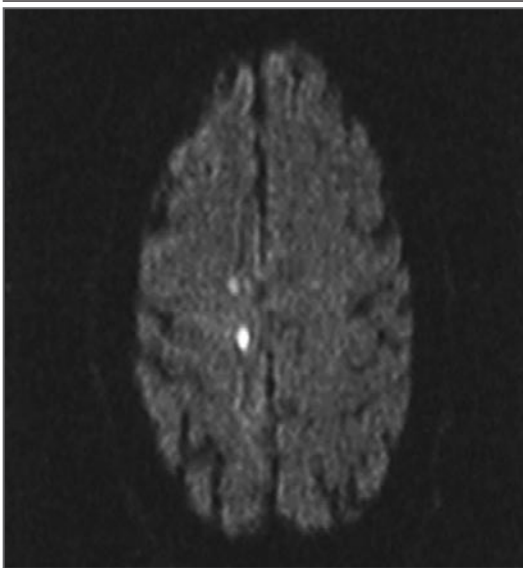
MRI Scan Showing Embolic Infarcts in a 74-Year-Old Man with Stroke after CABG.
